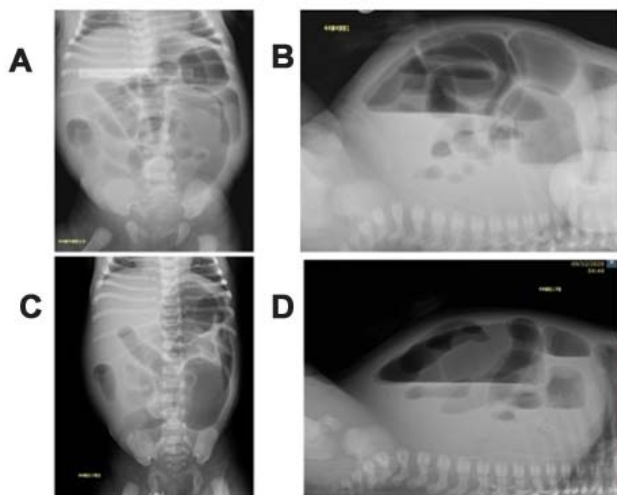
Plain and decubitus view of abdominal radiographs after birth-Case 4
